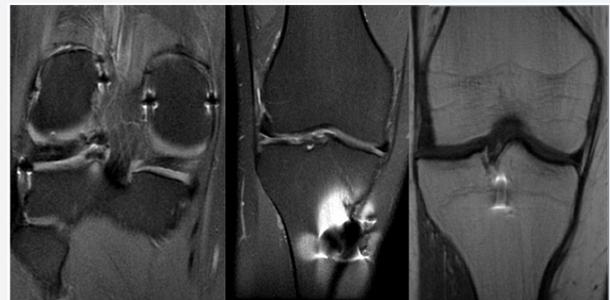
Coronal images of MRI enhanced in DP sequence with fat suppression (both on the left) and in FSE T1 (the one on the right) showing various artifacts of magnetic susceptibility by the surgical material: artifacts by sutures and by tunnels bone at the tibial level.
